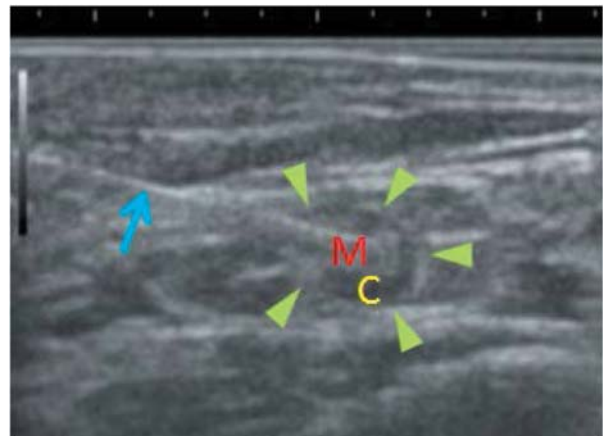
Ultrasonography showing access to the groin lymph node (arrowhead) with a needle (arrow). The cortex (C) is a low-echoic lesion, the medulla (M) is a high-echoic lesion.
